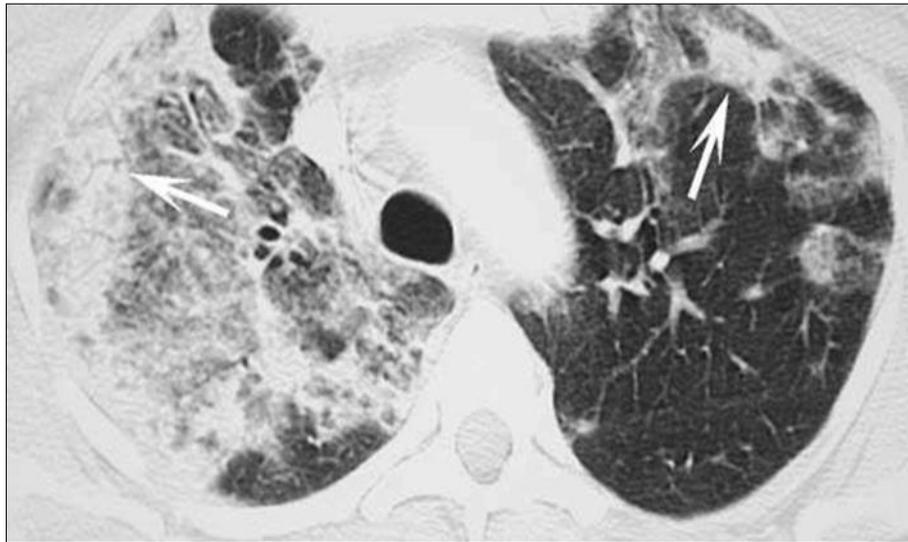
Consolidation on HRCT imaging (pointed by white arrows).
